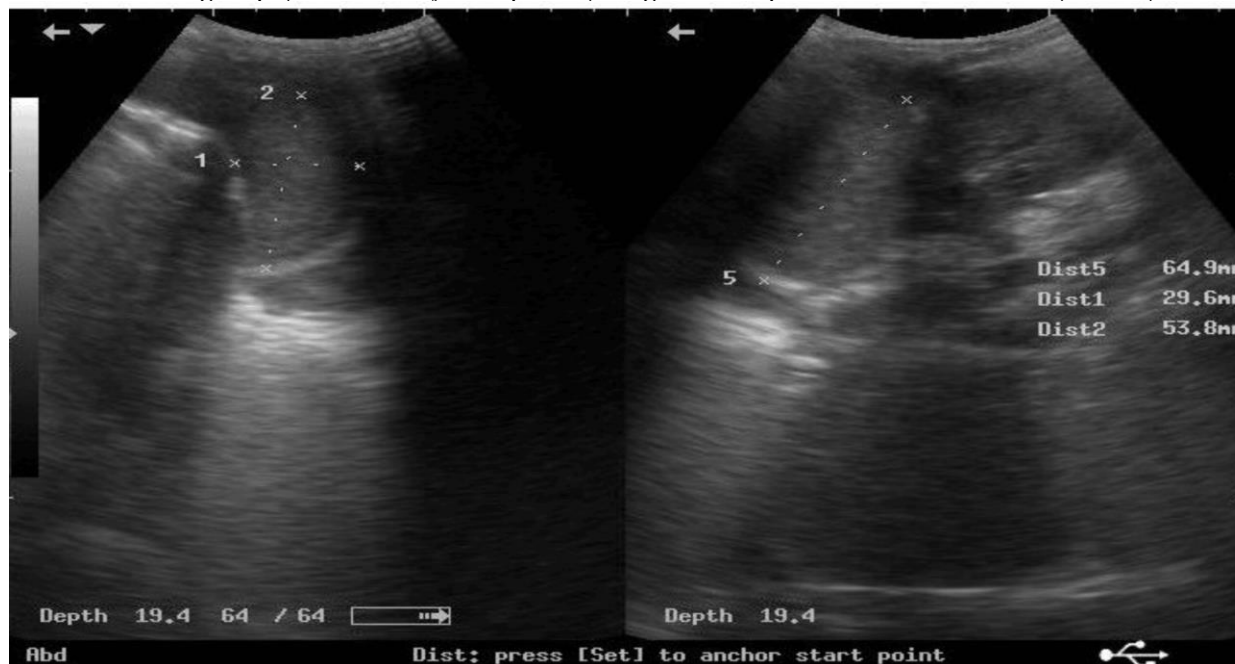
Ultrasound spleen image of the 9-year-old male SCD subject
